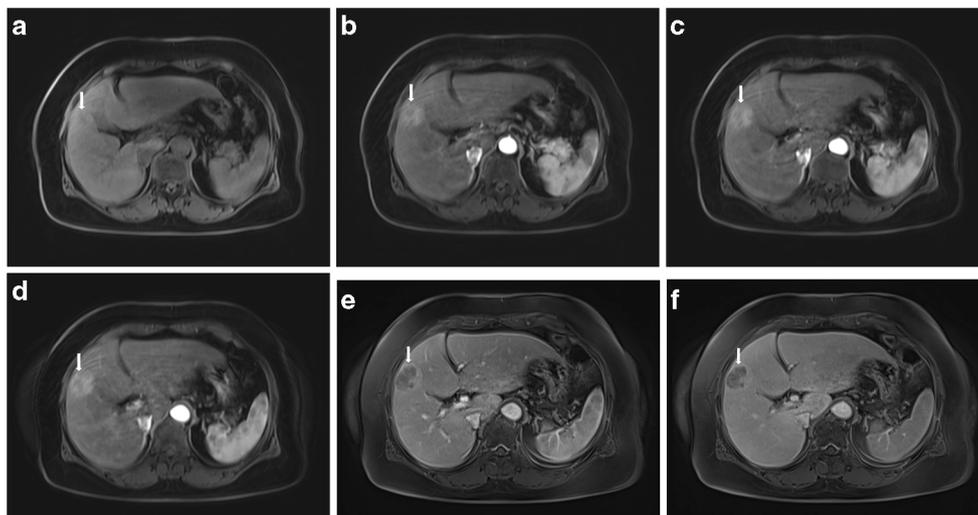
Fifty-eight-year-old man with chronic hepatitis B on gadoxetic acid-enhanced liver MR examination using CDT-VIBE sequence with view-sharing. MR images in (a) pre-contrast, (b) first arterial, (c) second arterial, and (d) third arterial phases, (e) portal venous phase, and (f) transitional phase. Note moderate motion artifact with some, but not
